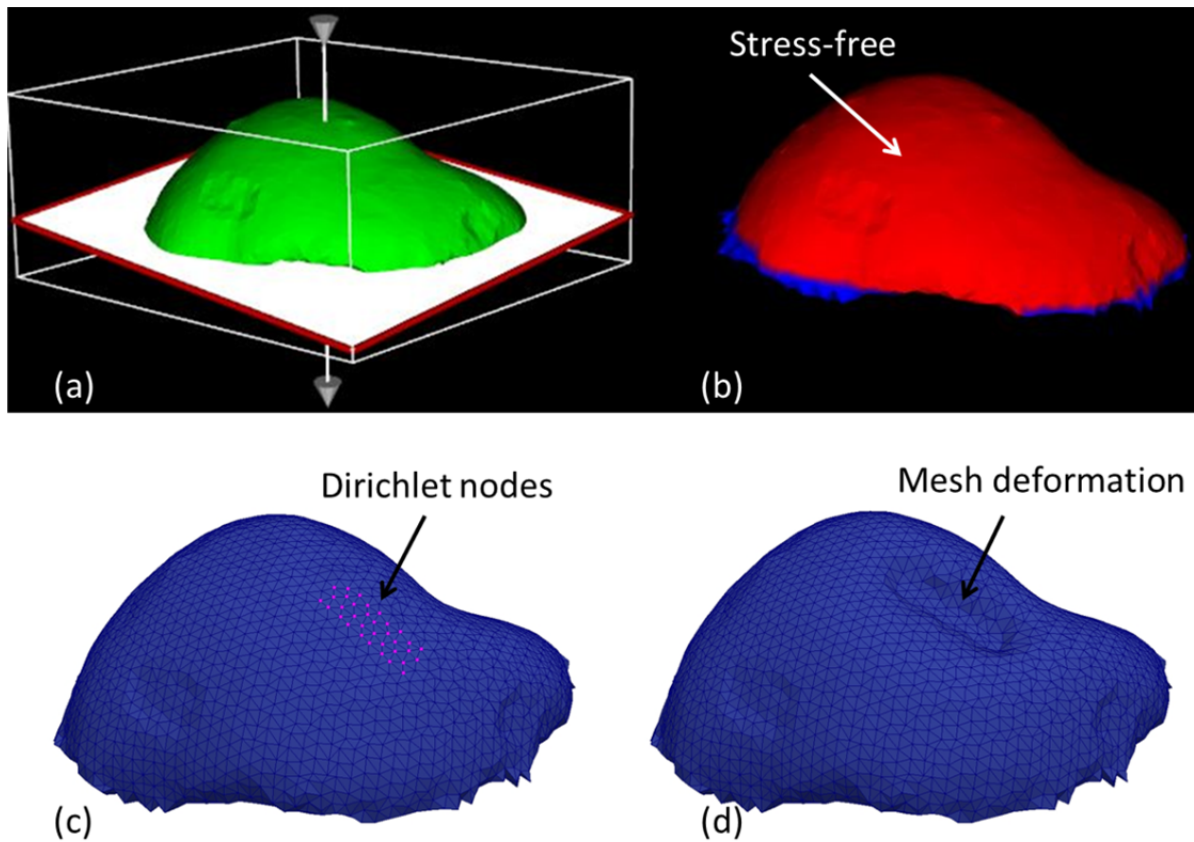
Initial boundary conditions were assigned manually (a) to designate the bottom fixed, and the top as stress free (b). These boundary conditions were then modified for each model-based correction by changing the appropriate nodes to Dirichlet displacement conditions (c) based on the position of the ultrasound probe surface, and then the model was solved to produce an approximation of the deformed tissue (d).
